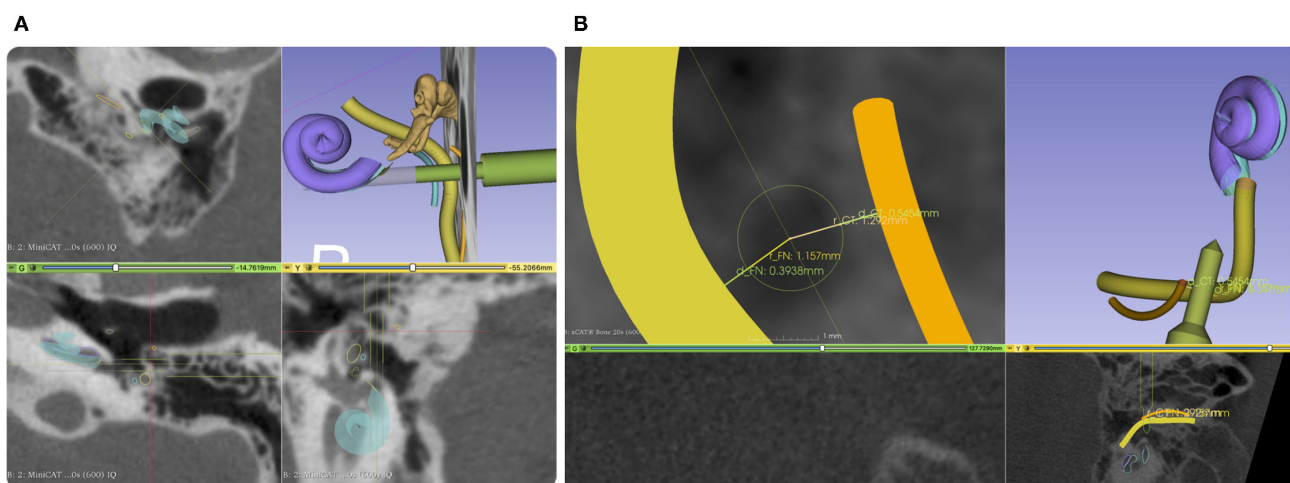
(A) Screenshot from our planning software. An access path (green) is planned with a diameter of 1.5 mm and 3 mm through the facial recess. The facial nerve (FN) is shown in yellow and the chorda tympani (CT) in orange. (B) A close-up of the projection view in the direction of the planned drill path. Here, we do not measure the width of the facial recess but the effective width referred to the central axis of the planned access path. To better compare drill diameter to the facial recess width, we report two distances, one for each nerve.
